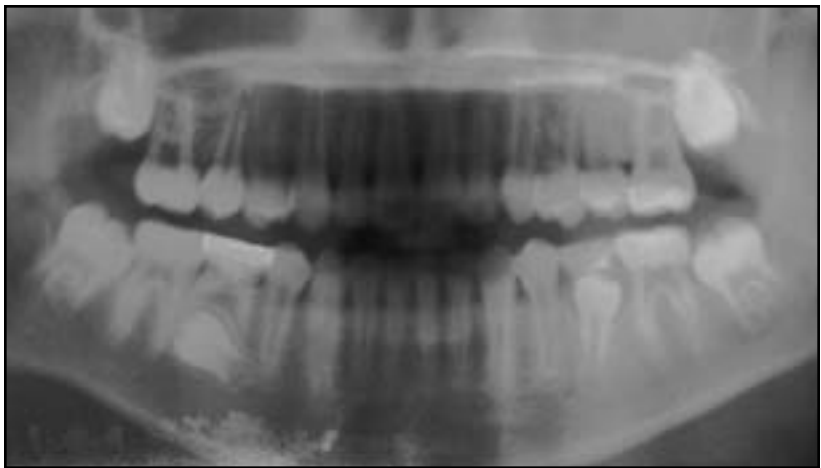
Initial panoramic radiograph shows horizontal position of mandibular right second bicuspid.
